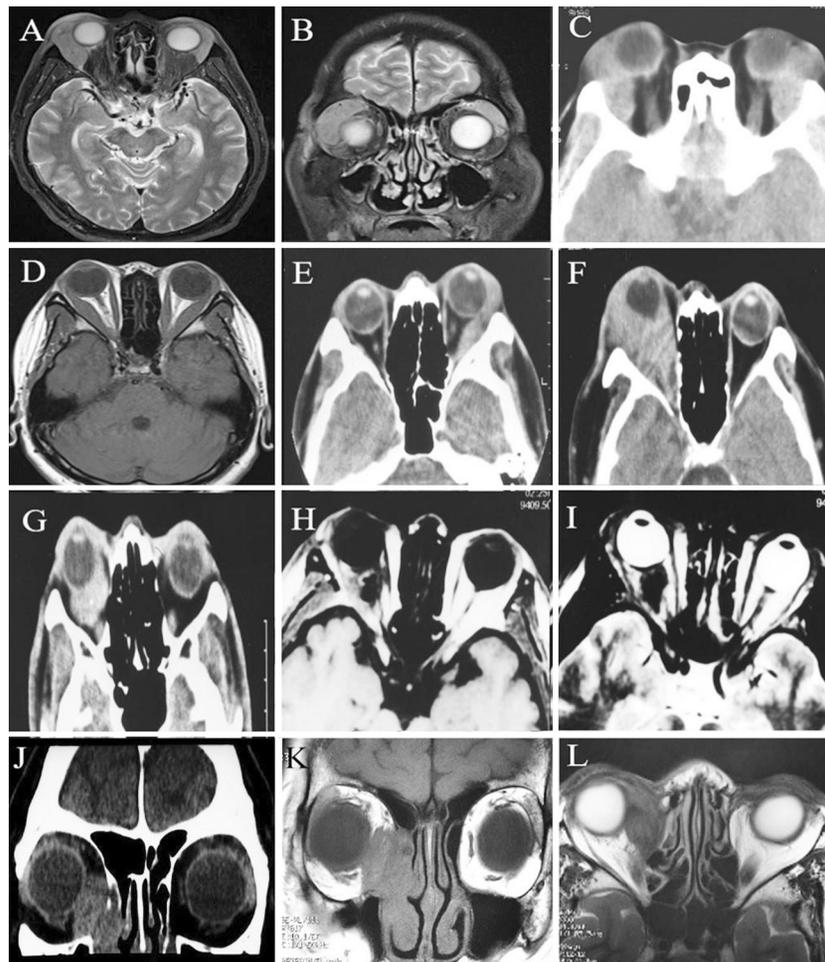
CT and MRI images of different subtypes of pathologically confirmed NSOI A, B, C: MRI (diffuse enlargement of the lacrimal gland, isotropic T1 and short T2 signals, well-defined fat suppression borders, prominent enhancement on enhancement imaging, neighboring extraocular muscles can be involved or displaced) and CT images (amygdaloid enlargement of the lacrimal gland with homogeneous increase in density, partial infiltration of the surrounding tissues, and absence of bone destruction) of lacrimal gland type NSOI. D, E: MRI (thickening of the tendon and muscle belly of the lesion muscle, isotropic T1, short T2 signal, moderate enhancement on enhancement imaging) and CT images (thickening of the tendon and muscle belly at the same time, blurred borders, and no bony destruction) of the myotropic type of NSOI. F, G: CT images of the diffuse type of NSOI (the lesion is more extensive, characterized by thickening of the extraocular muscles, lack of clear demarcation of the extraocular muscles from the lesion, enlarging of the lacrimal gland, thickening of the ocular ring, and enlargement of the optic nerve. The ocular ring exhibits thickening, potentially encircling the optic nerve, which demonstrates enhancement without affecting the optic nerve. Typically, intraorbital low-density fat shadow is replaced by soft tissue density shadow. H, I: MRI images of posterior (orbital apical) NSOI (isometric T1 signal, long T2 signal, moderate-significant enhancement on enhancement scan. J, K, L: Images of bone-destroying type NSOI (CT and MRI: soft tissue density shadow visible in the orbital septum, with a relatively homogeneous density, generally without calcification, limited destruction of the orbital bone in the inner and lower walls is missing, and the lesion involves extra-orbital tissues. MRI: Isotropic T1 signal, inhomogeneous short T2 signal. NSOI: Nonspecific orbital inflammation; MRI: Magnetic resonance imaging; CT: Computed tomography.
